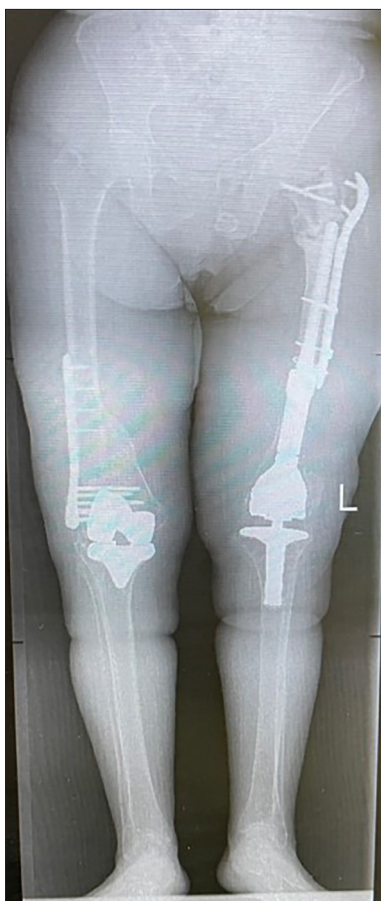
Radiograph of both lower extremities. The right knee prosthesis and healed right femoral fracture with fixation hardware are visible. In the left lower extremity, a Biomet OSS prosthesis is present, along with a subtrochanteric periprosthetic fracture stabilized with a proximal femoral plate (ChM) and no radiographic evidence of union (4 months after presentation).
